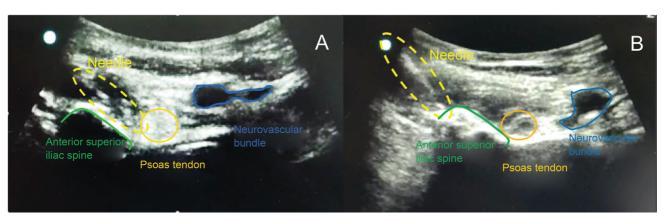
Ultrasonographic appearance of the structures with good positioning (A). Ultrasound appearance of the poor-positioned structures (B).
